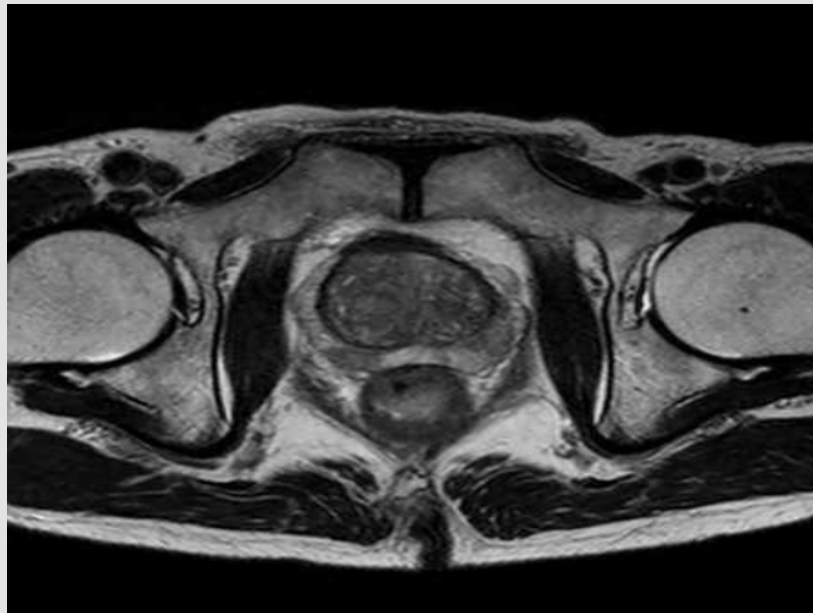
MRI showed large prostate adenoma; however, the margin is smooth with no lymph node swelling.
